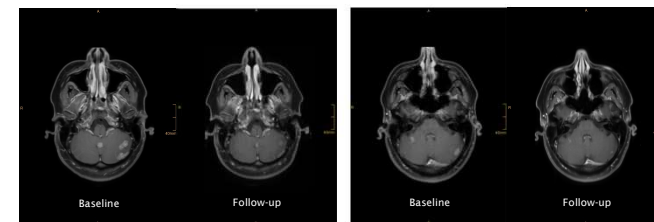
Intracerebral response on cerebral MRI
